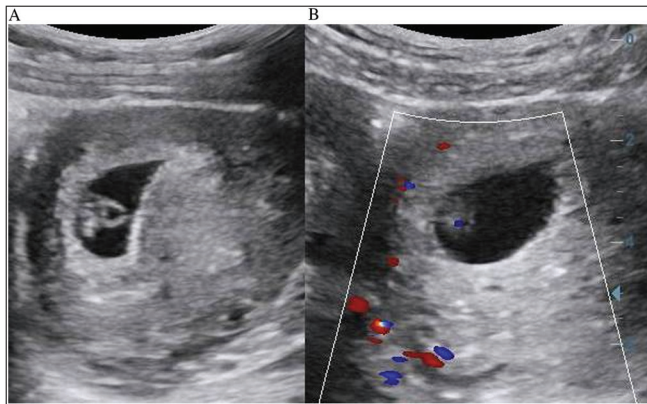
(A) Ultrasound image of gestational sac at transverse view showed chorionic villi on right lateral side of sac. (B) Longitudinal view showed posterior location of chorionic villi
